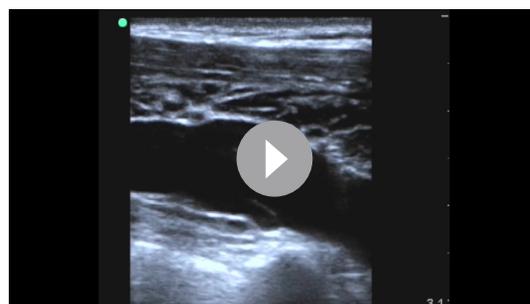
Incidental upper extremity deep venous thrombosis. (A) A mobile upper extremity deep vein thrombus adherent to a venous valve was detected incidentally in the proximal right axillary vein during a prebronchoscopy lung ultrasound examination. (B) Complete resolution of the deep venous thrombosis is seen over the same valve after 4 weeks of anticoagulation.
